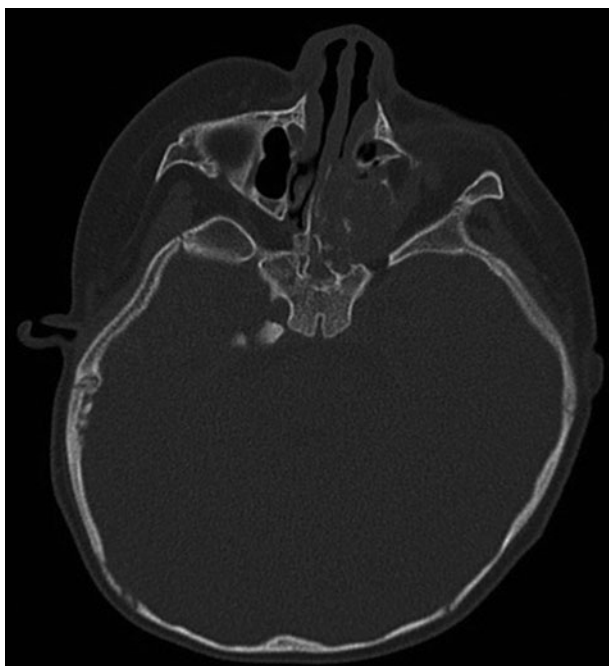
Pre-operative axial plane computed tomography image for patient 2.
